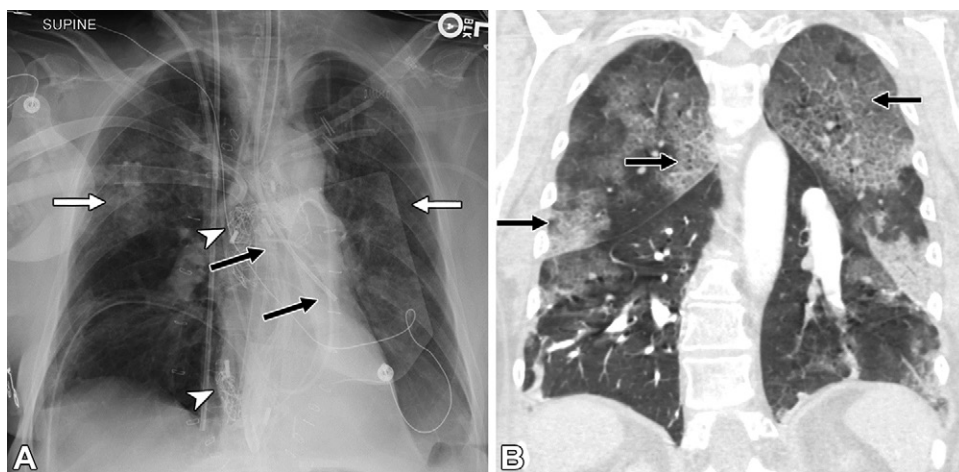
Hemorrhage in a 68-year-old woman after PTE for CTEPH complicated by intraoperative hemorrhage. (A) Chest radiograph shows an open chest with surgical packing material (arrowheads). A catheter (black arrows) extends down the left main-stem bronchus, which represents an endobronchial blocker that is used to reduce hemorrhage and hemoptysis. This can be mistaken for a misplaced enteric tube. Bilateral parenchymal opacities (white arrows) in this context are suggestive of hemorrhage. (B) Coronal CT image 5 days later shows ground-glass opacity and septal thickening, resulting in a crazy paving appearance (arrows), also compatible with hemorrhage.
